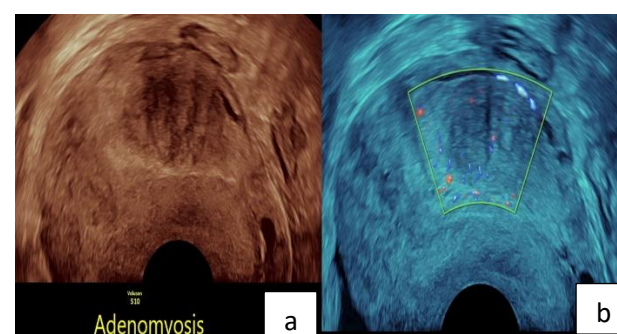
(a and b): Sonographic findings in adenomyoma. Heterogenous ill-defined solid lesion within the myometrium with translesional minimal flow on Doppler mapping. Associated diffuse adenomyosis.
